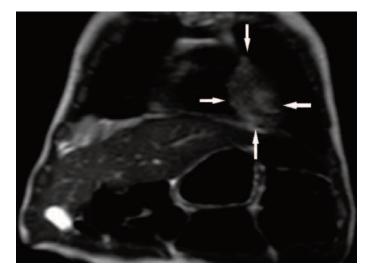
Magnetic resonance imaging in coronal view showing a mass in the apical area.
